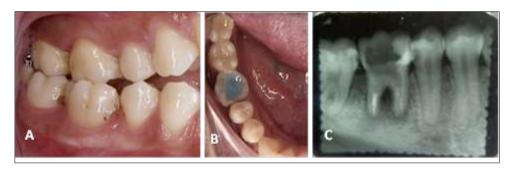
Baseline. (A & B) Clinical photographs. (C) Periapical radiograph of tooth 46
